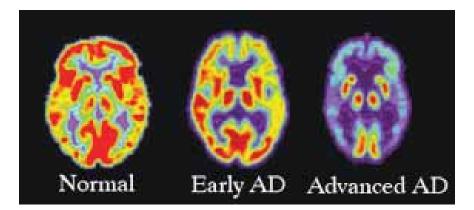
PET CT Brain of Alzheimers Disease
